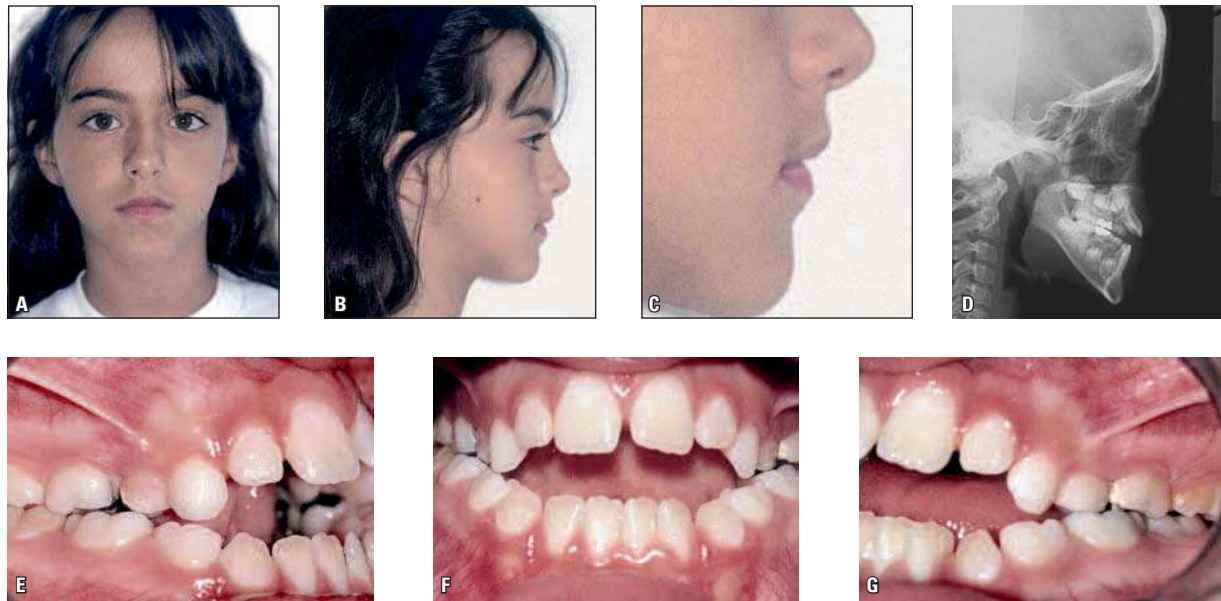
Initial extraoral photographs (A, B, C), lateral cephalometric radiograph (D) and intraoral photographs (E, F and G).
